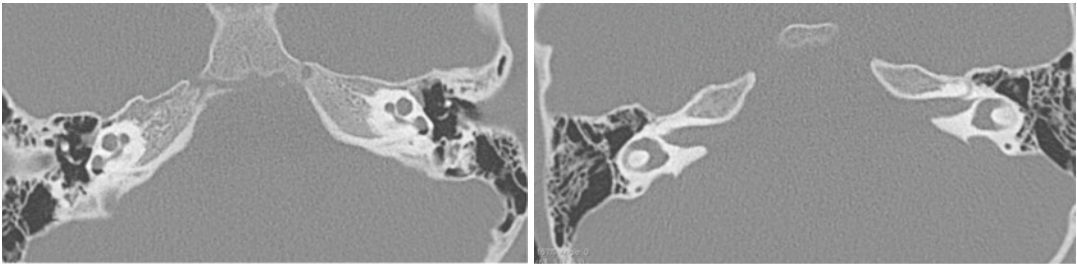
A computed tomography scan of a female patient who had progressive bilateral mixed hearing loss, affecting the low frequencies. Figure in the left side:
